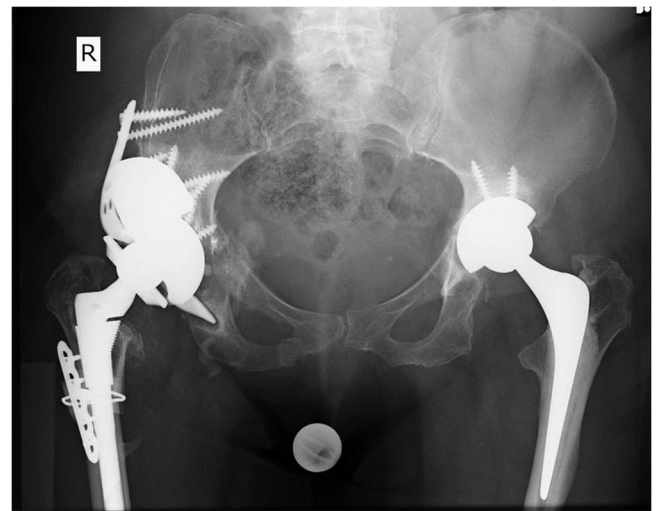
Post-operative AP radiograph showing the reconstructed right hip.
